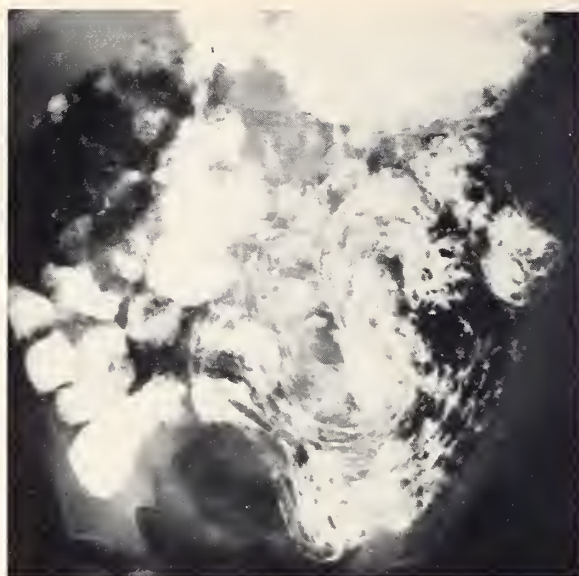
X-ray film of small intestine of a three-and-one-half-year-old white girl admitted with a fractured femur. She had a cough due to an upper respiratory tract infection but no gastrointestinal symptoms. She had passed ascaris per nares and per rectum. The small intestine study with a barium meal shows multiple curvilinear and several round or oval translucent filling defects in the contrast medium due to barium displacement by the worms.
